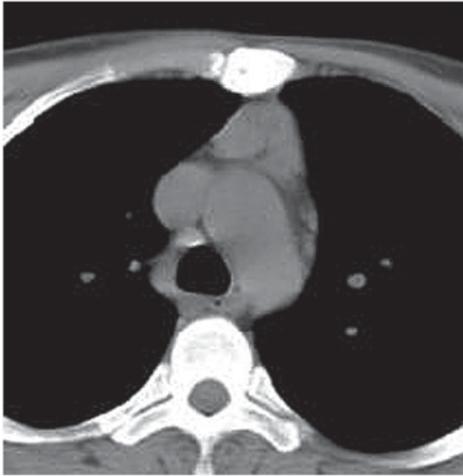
Unenhanced computed tomography image of a male myasthenia gravis patient (age, 18 years) with lymphoid follicular hyperplasia. The thymus is triangular in shape and may be easily distinguished from adjacent tissue.
